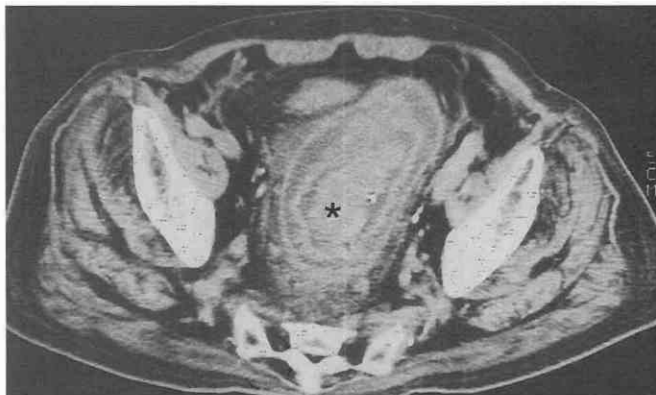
Pseudomembranous colitis. CT scan shows marked bowel wall thickening of the sigmoid colon and rectum (asterisk), producing a target appearance. Diffuse pericolic and perirectal infiltration is seen.
